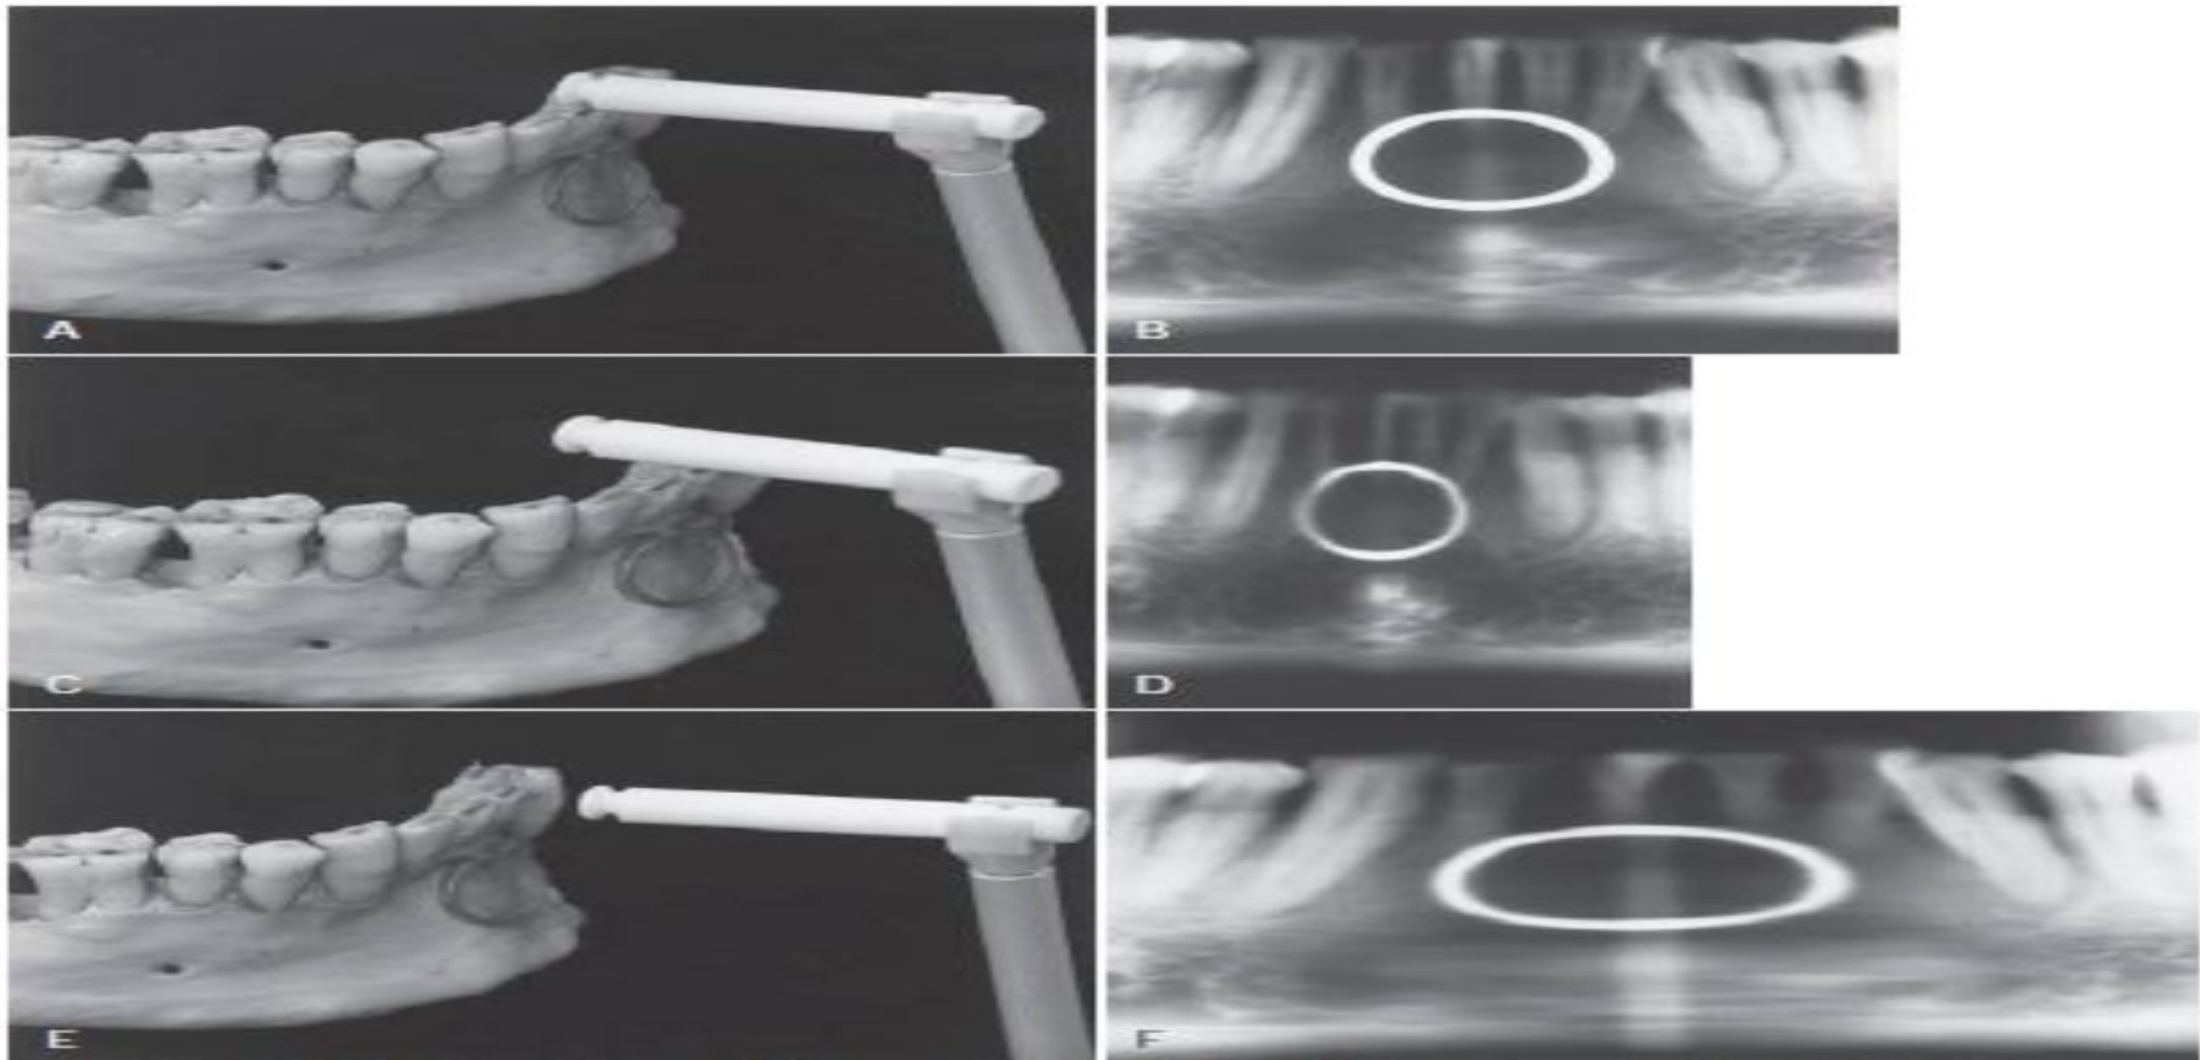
A, Mandible supporting a metal ring positioned at the center of the focal trough. The incisal edges of the mandibular teeth are indexed by a bite rod-positioning device. The mandible is positioned at the center of the trough. B, Resultant panoramic radiograph. C, Mandible and ring positioned 5 mm anterior to the focal trough. The incisal edges of the teeth are anterior to the trough. D, Resultant panoramic radiograph demonstrating the horizontal minification of both ring and mandibular teeth. E, Mandible and ring positioned 5 mm posterior to the focal trough. The incisal edges of the teeth are also posterior to the trough. F, Resultant panoramic radiograph demonstrating the horizontal magnification of both ring and mandibular teeth.
